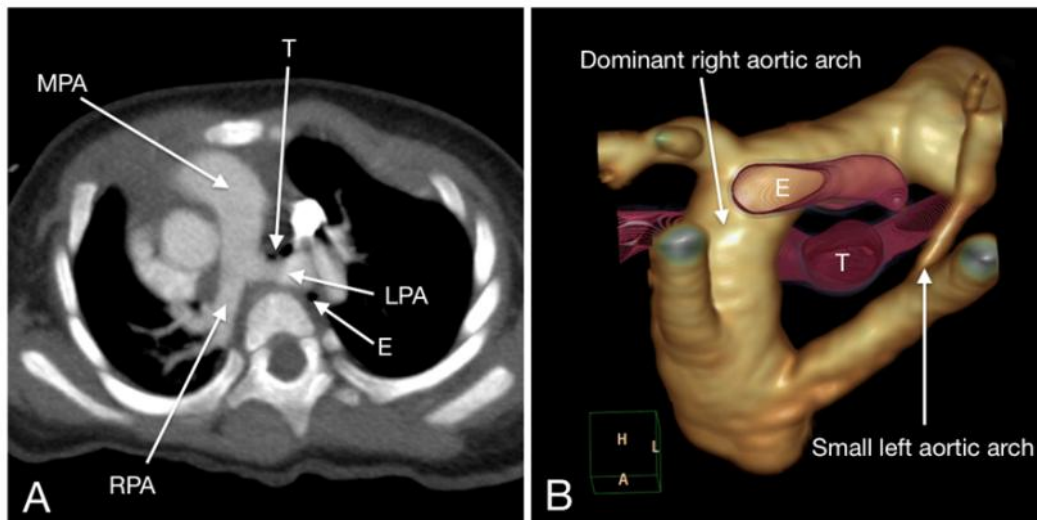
CT images of pulmonary sling and vascular ring. A, Axial MIP image demonstrates the aberrant left pulmonary artery (pulmonary sling) arising from the right pulmonary artery passing between the trachea and esophagus. B, Volume rendered image showing double aortic with dominant right arch and hypoplastic left arch forming a vascular ring that surrounds the trachea and esophagus. MPA = main pulmonary artery, RPA = right pulmonary artery, LPA = left pulmonary artery, T = trachea, E = esophagus.
